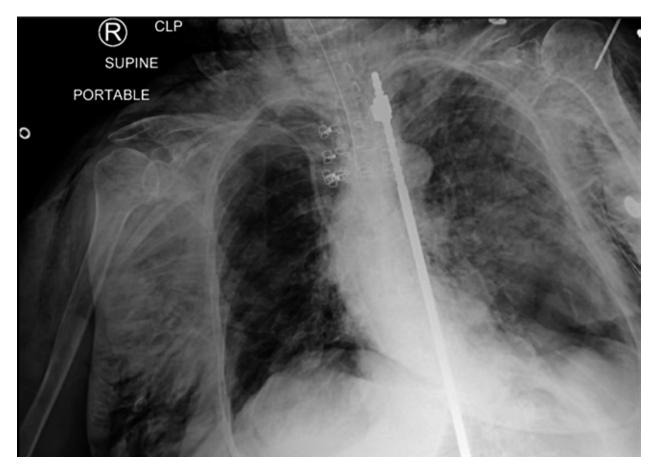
Chest radiograph demonstrating bilateral pneumothoraces with tension, resulting in a compressed mediastinum, and massive subcutaneous emphysema.
